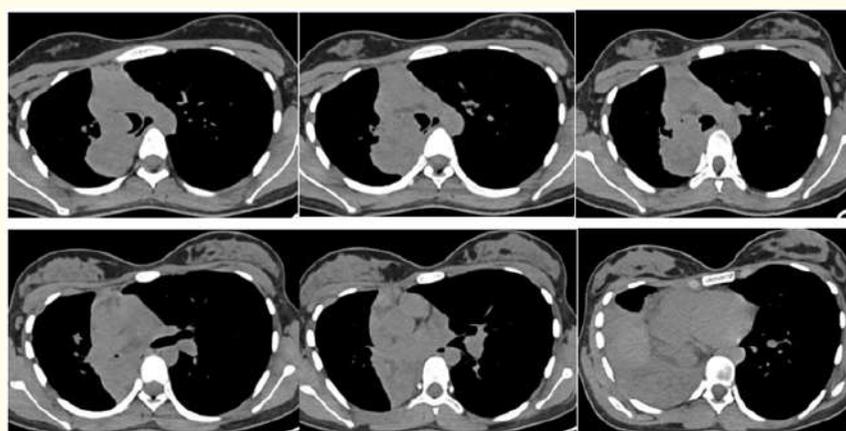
Axial (A-F) Non-contrast Computed Tomography images show a multilobulated isodense mass in the distal trachea extending to the right lower lobe bronchus with significant extraluminal component causing abrupt cut off of the bronchus intermedius causing lower lobe collapse.
